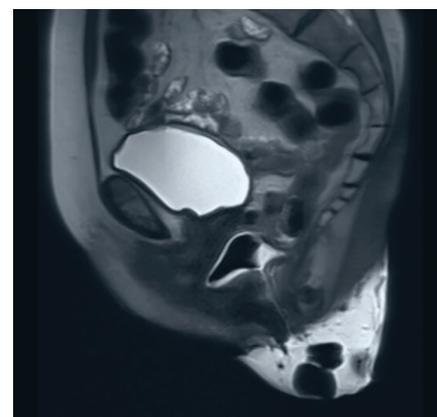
Sagittal T2 MRI image at rest of woman with vault prolapse and symptoms of obstructive defecation.
